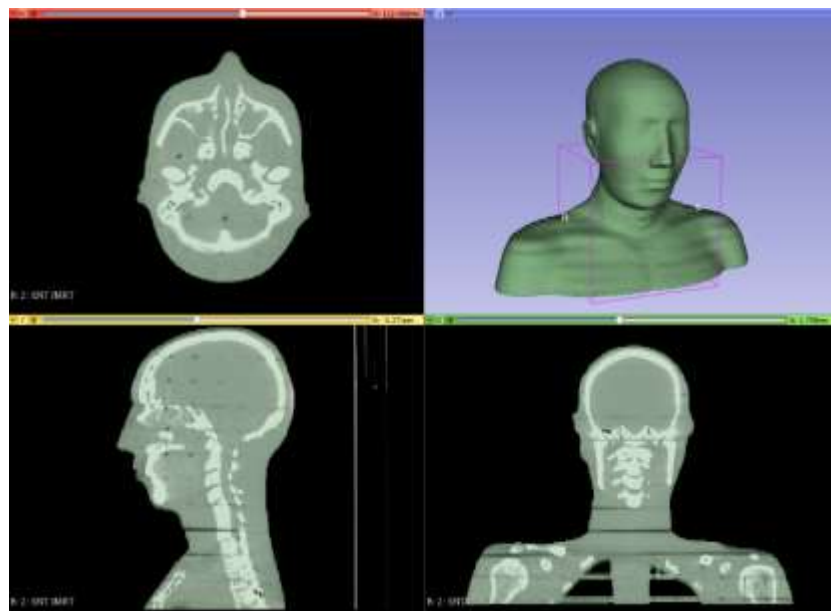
Modelling of the patient's head in 3D Slicer from a CT scan.
